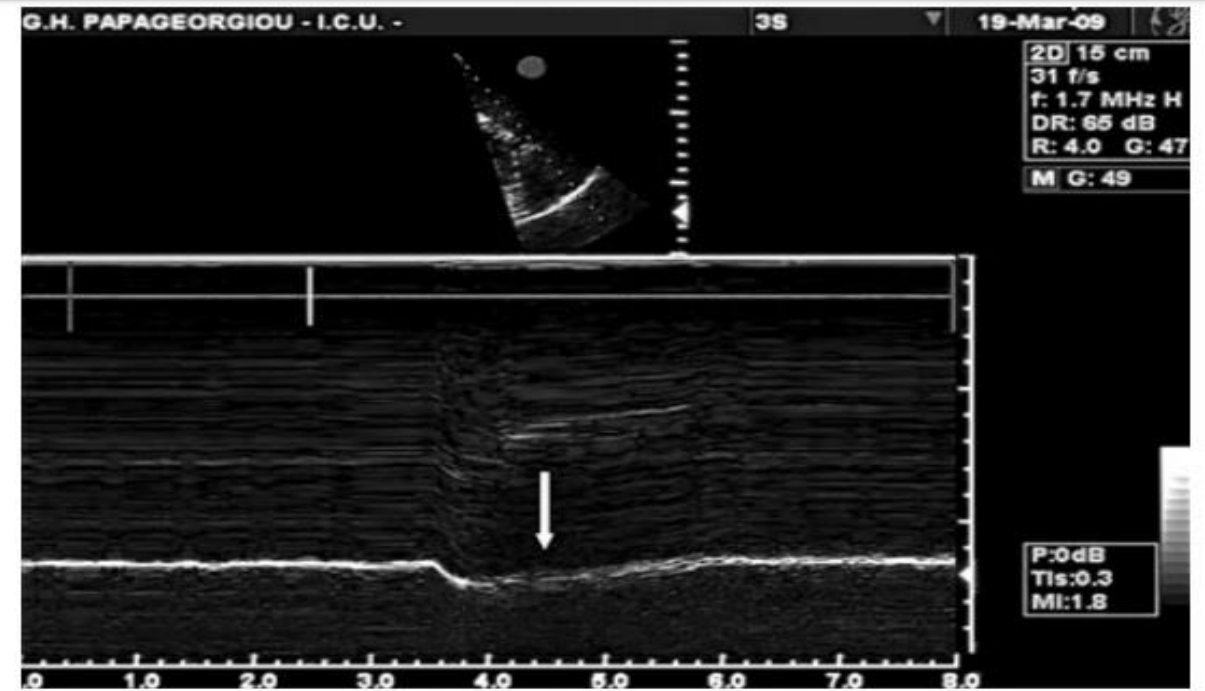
Paradoxical diaphragmatic motion on M-mode sonography in a patient with Guillain-Barré syndrome (the *scale* at the *bottom* represents time in seconds). There is a cranial diaphragmatic movement (away from the probe) during spontaneous breathing due to diaphragmatic paralysis. The intercostal muscles recover earlier than the diaphragm and create a negative intrathoracic pressure which displaces the paralytic diaphragm inwards, into the thorax and away from the probe
